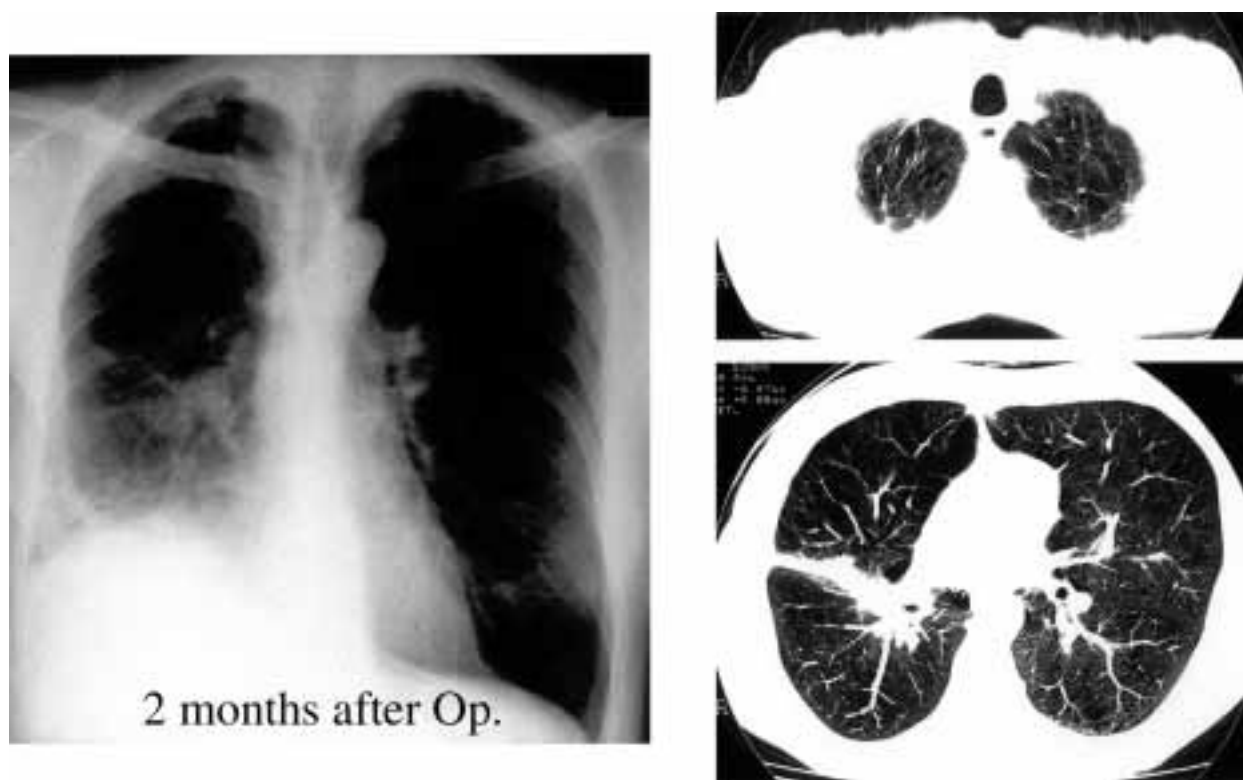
Left: Postoperative plain chest X-ray showed volume reduction of the right lung with dome formation of the right diaphragm. Right: Chest CT showed removal of the right middle lobe with a tumor and a giant bulla of the right upper lobe.
